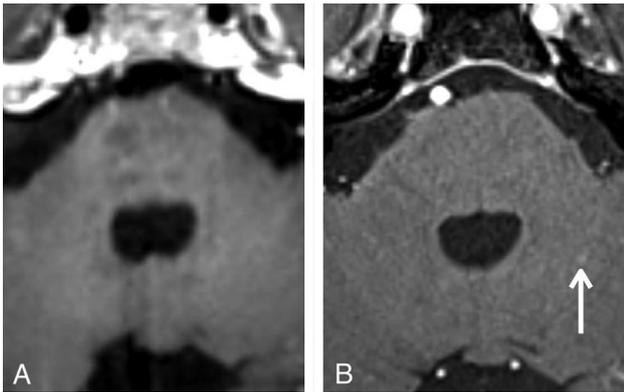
A 60-year-old lung cancer patient with a tiny enhancing lesion in the left cerebellar hemisphere (white arrow) that was not visible on contrast-enhanced 3D T1-weighted SPACE in head-to-head analysis. Axial contrast-enhanced 3D T1-weighted VIBE (B) shows a tiny enhancing lesion while contrast-enhanced 3D T1-weighted SPACE (A) shows no visible lesion.
